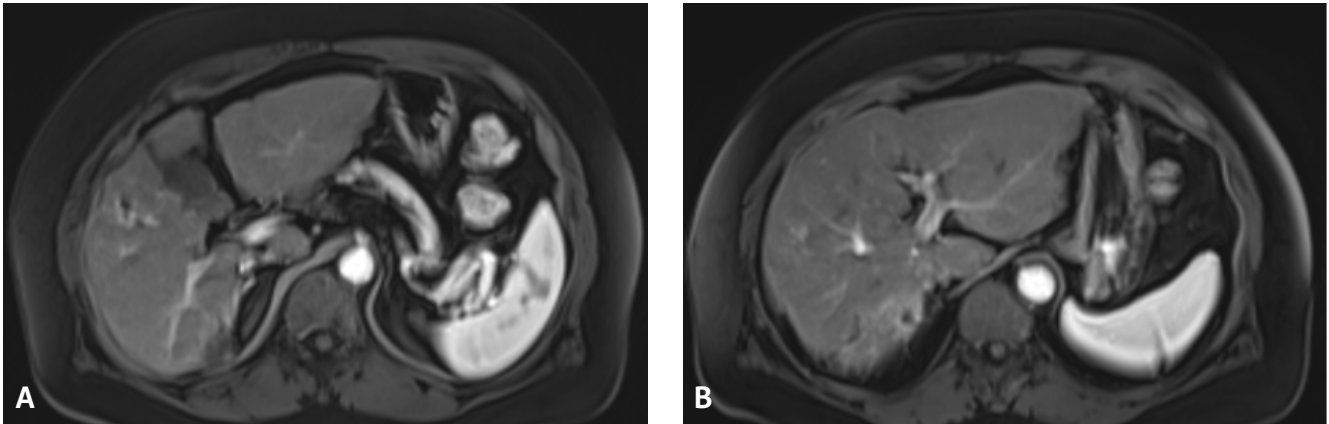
Three-month follow-up MRI post radioembolization demonstrated changes in the right hepatic lobe without residual or recurrent tumor at the location, compatible with treated non-viable lesions in (A) segment 5 and (B) segment 7.
